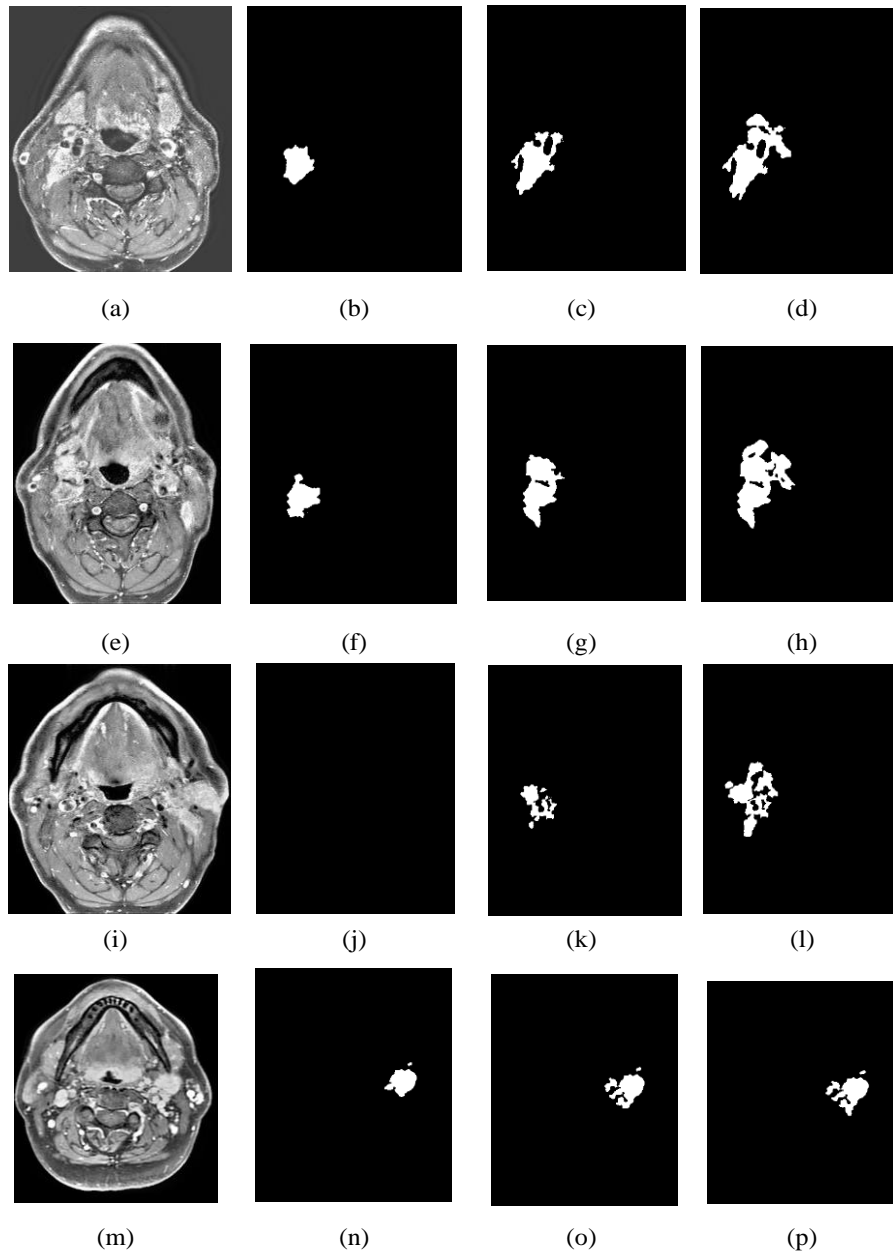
The evolution of LS function in MRI volume. (a)(e)(i) are three interpolated MRI slices at top, middle and bottom of same MRI volume (MR28082014). (b-d) are sliced volume ALN segmentation of top position changed following iterations. (f-h) at middle, and (j-l) at bottom. (m) is MRI slice from other interpolated MRI volume (MR14012013), (n-p) show their evolution.
